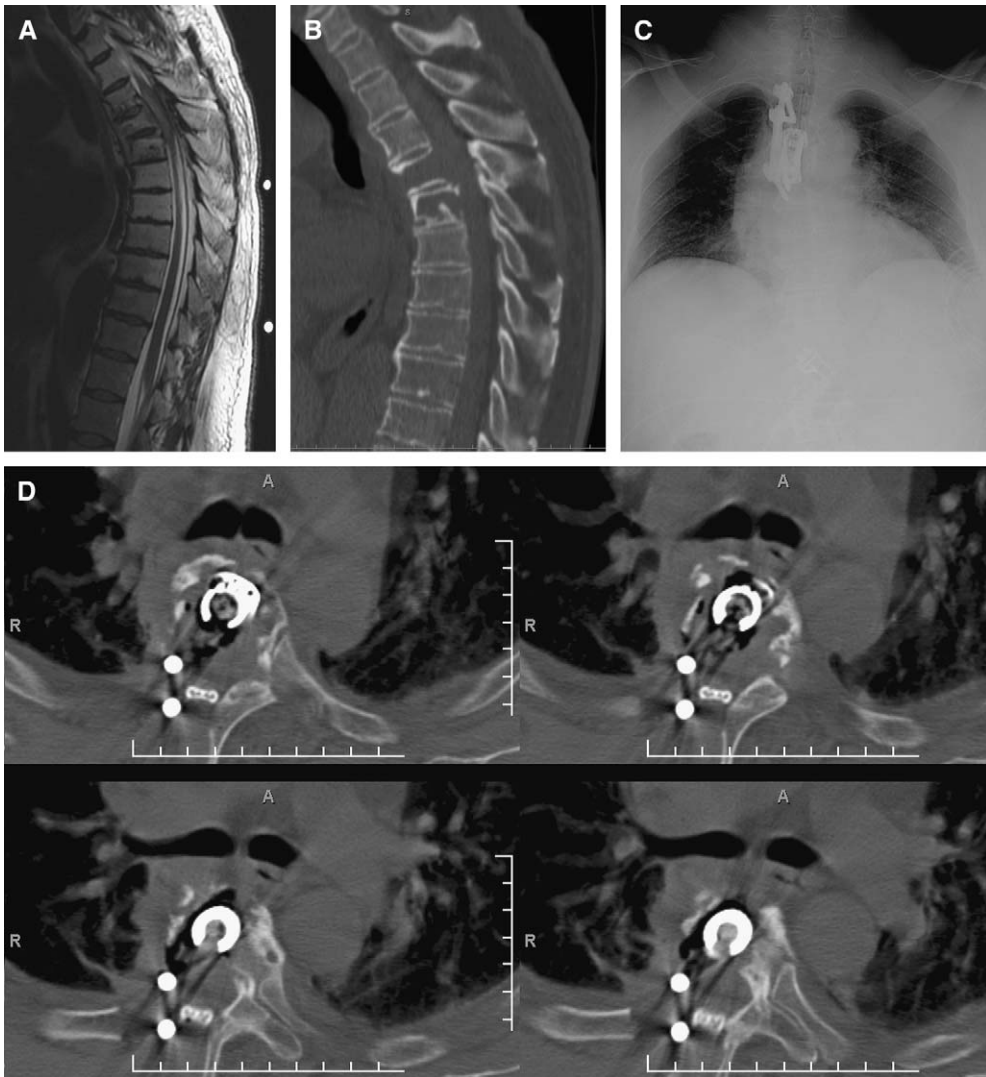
A 59-year-old man presented with chronically progressive myelopathy from thoracic plasmacytoma despite radiation therapy. (A) Sagittal T2-weighted MRI reveals plasmacytoma of the T4 and T5 vertebral bodies with collapse and epidural spinal cord compression. (B) Sagittal reconstruction of the CT scan of the same patient demonstrates replacement of the T4 and T5 bodies with tumor. (C) Anteroposterior radiograph of same patient after a right-sided minimal access LEC corpectomy of T4 and T5. The defect was reconstructed using an expandable titanium cage and ipsilateral vertebral body and pedicle screws with rod fixation. (D) Postoperative axial CT images show the extent of bone removal from a right-sided approach, with satisfactory placement of the autograft-filled intervertebral cage. The rods connecting the screws are seen on the right side of the defect, and a surgical drain is seen overlying the laminectomy site. A, anterior; R, right.
